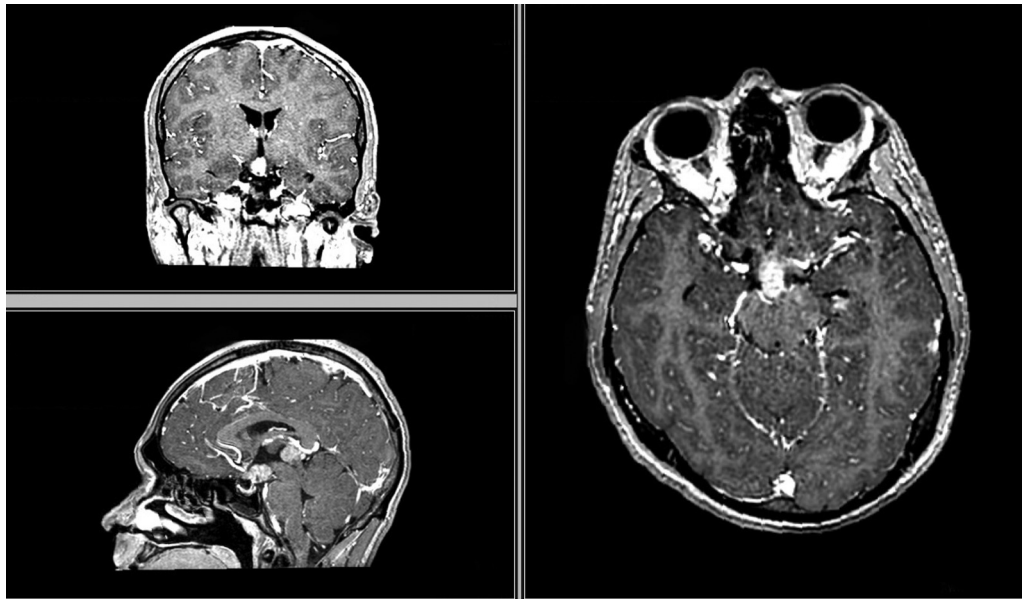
The magnetic resonance imaging (MRI) demonstrated contrast-enhancing lesions involving both suprasellar and pineal gland regions.
